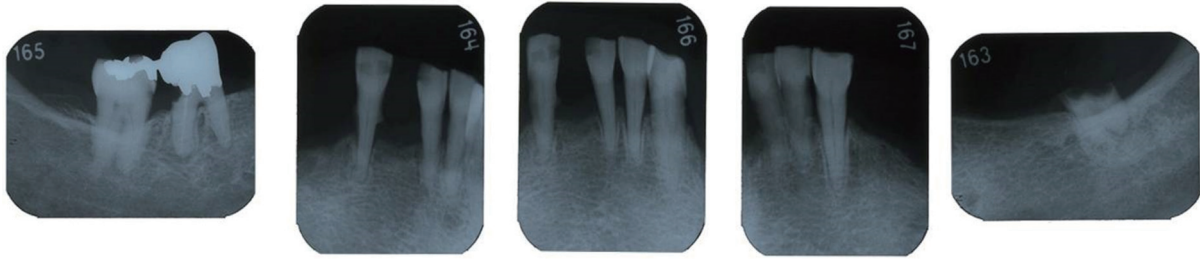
Dental X-rays of the lower remaining teeth
